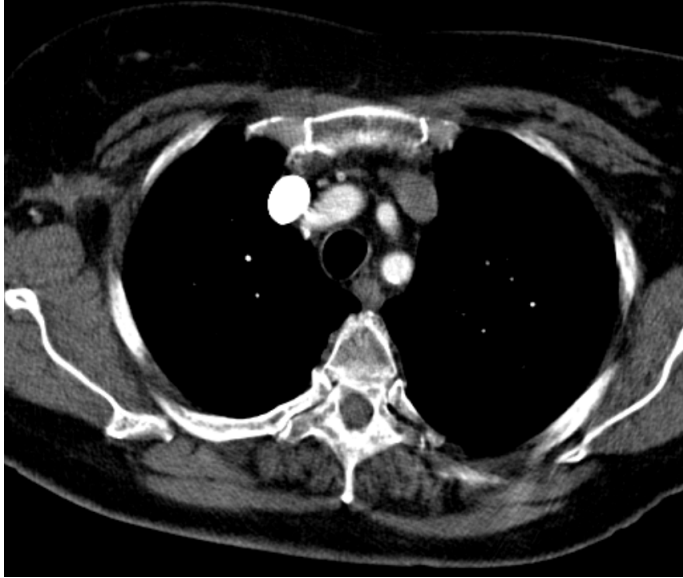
An example of a CT thorax image in the axial plane.
